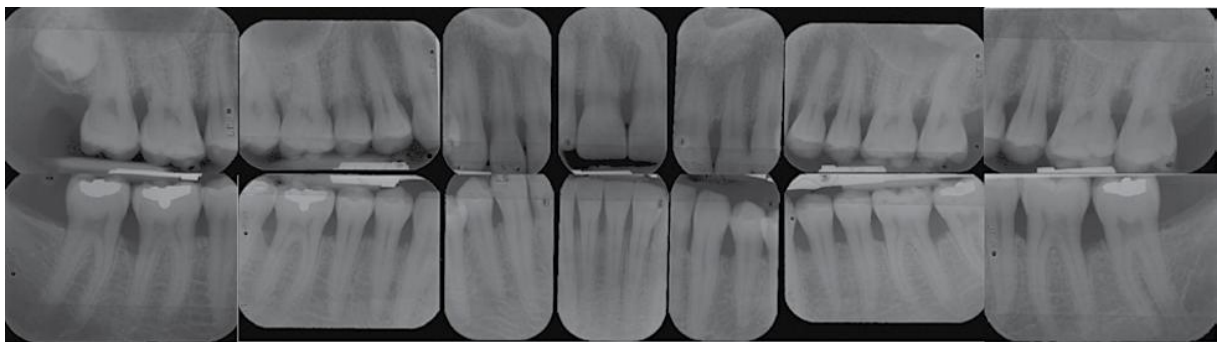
Radiographs of the patient presented in Fig. 32-17.
